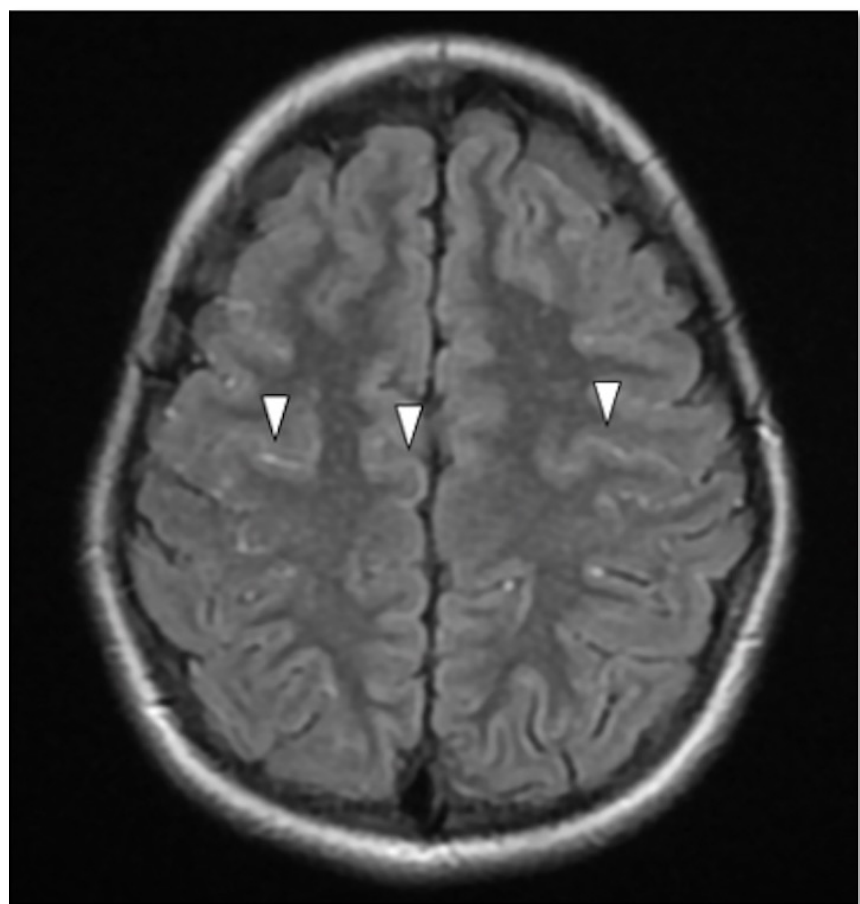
MRI FLAIR sequence showing ivy sign (arrowhead) seen as linear high signals that follow a sulcal pattern (white arrowheads).
